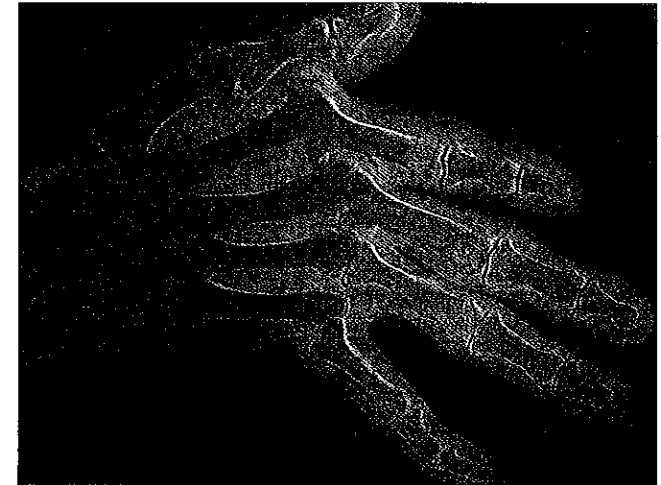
X-ray image of a hand deformed by rheumatoid arthritis.
